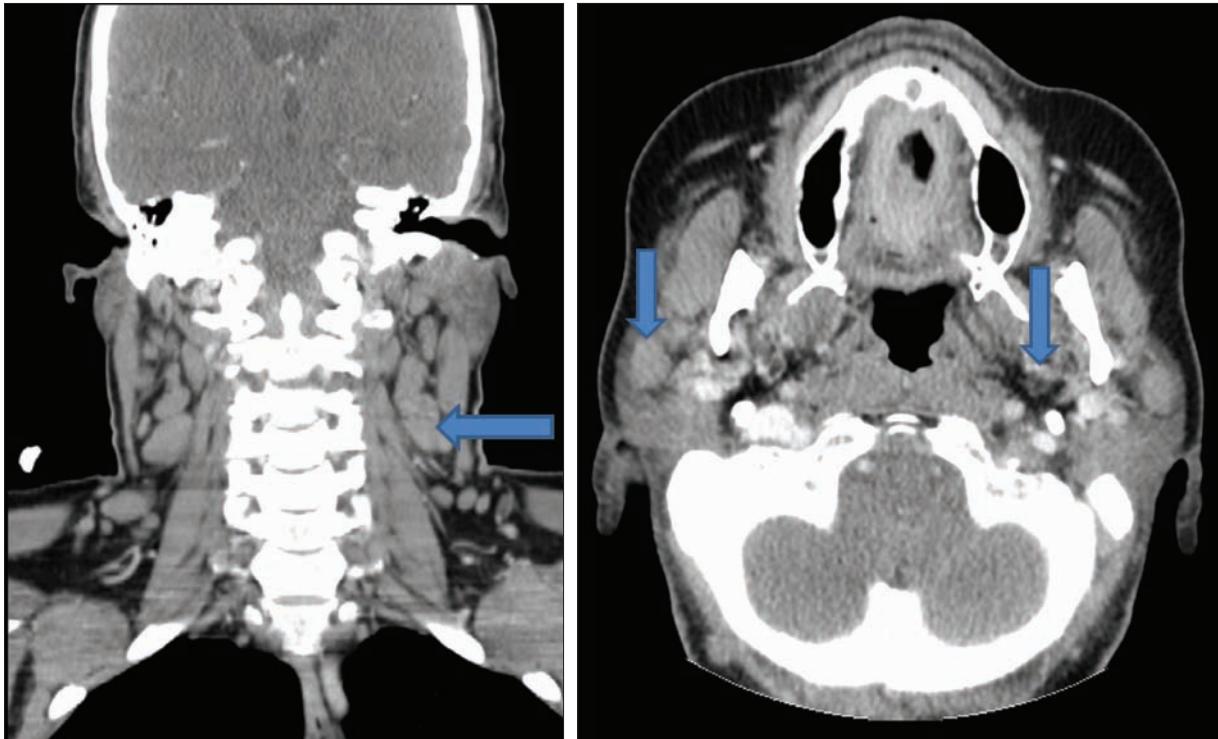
CT of the neck soft tissues demonstrating prominent cervical lymphadenopathy.
